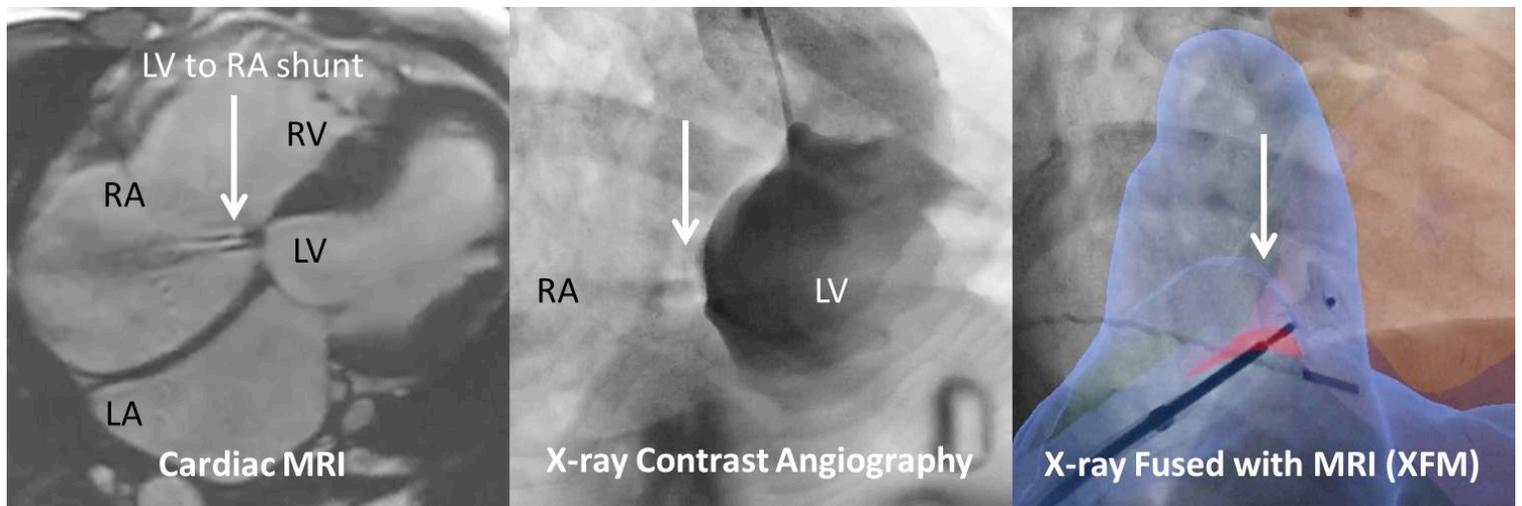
X-ray fused with MRI (XFM) guided device closure of left ventricle to right atrium shunt.
